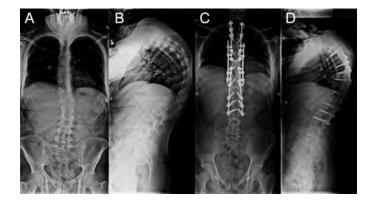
Pre (A, B) and postoperative (C, D) sagittal and coronal standing scoliosis radiographs after En Bloc Reduction-Fixation Using Intercalary Rods in an adult patient.
